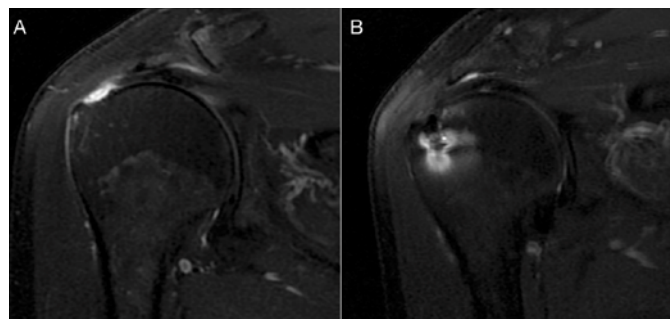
MRI. A: Preoperative oblique coronal image demonstrating full-thickness tear of the supraspinatus; B: Complete repair, with Sugaya type I classification (sufficient thickness with low signal in all cuts).
